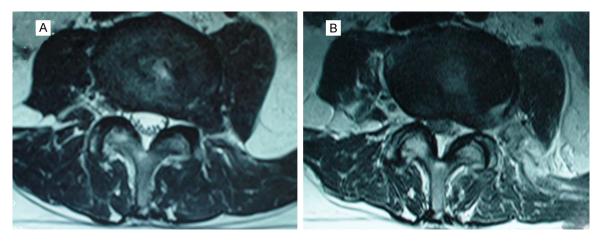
MRI cross-sectional images before and after collagenase chemonucleolysis. A: Preoperative cross-sectional image of herniation (T2 image) with extraforaminal lumbar disc herniation; B: Postoperative cross-sectional image of herniation (T2 image): herniation is bigger than before. T2 image shows higher signal intensity.
